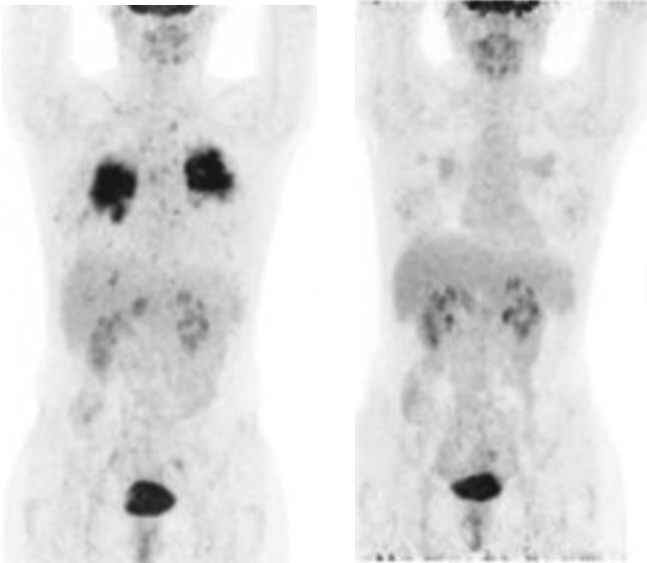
Example of ^{18}F -FDG PET in a patient with pulmonary sarcoidosis before (left) and after (right) 26 weeks of Inflectra® treatment.
